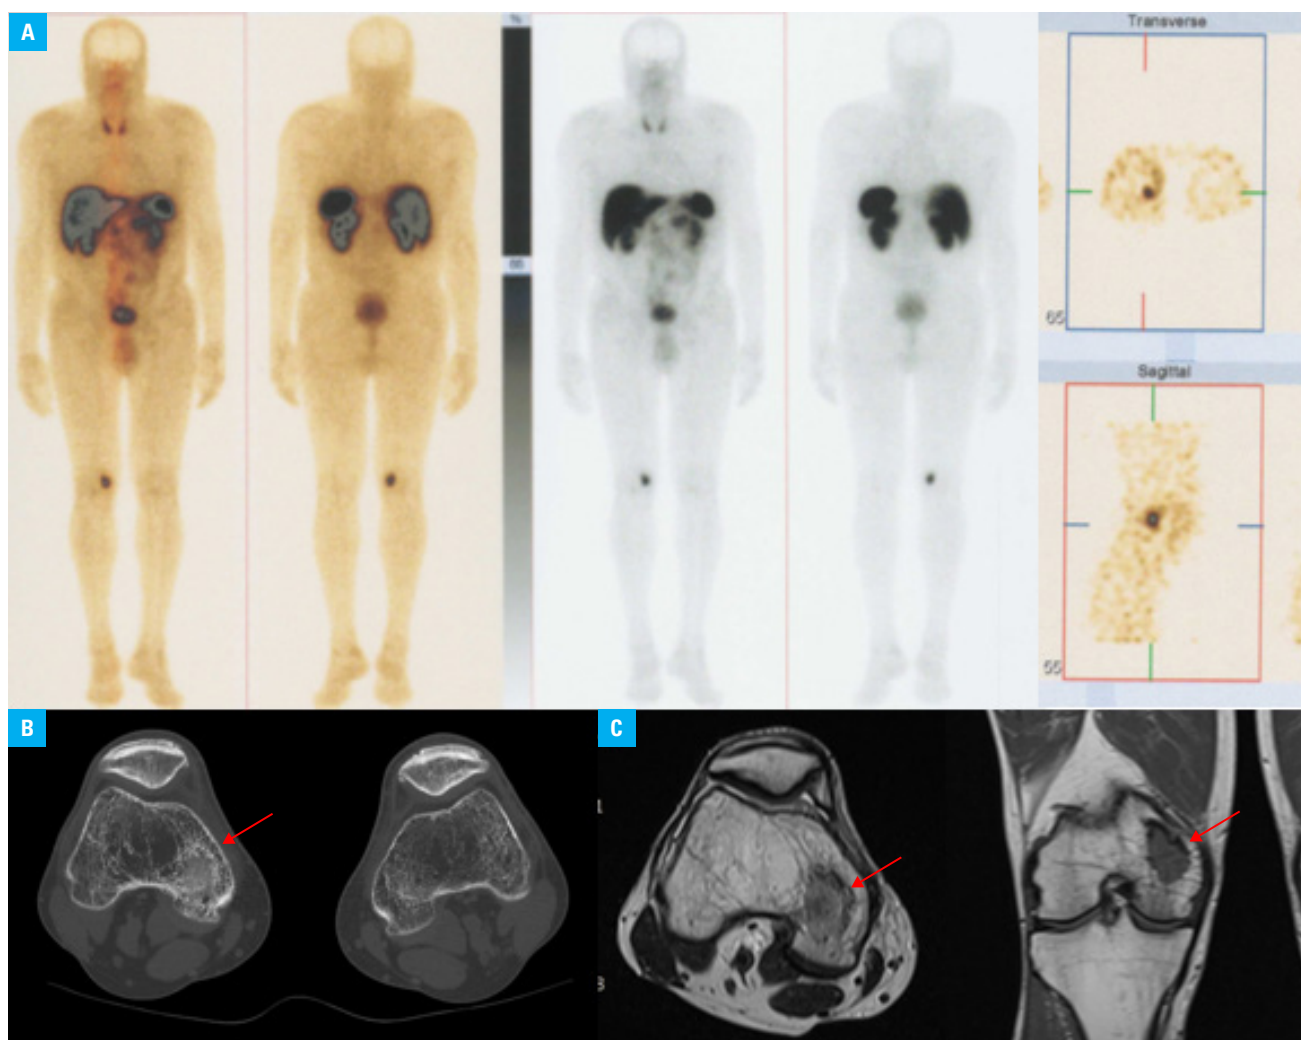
A – somatostatin receptor scintigraphy (^{99m}Tc -EDDA/HYNIC-Tyr3-octreotide): intense pathological radiotracer uptake in the right femoral epiphysis; B – computed tomography scan (transverse) of the right and left femoral epiphysis, with a visible phosphaturic mesenchymal tumor of blurred margins ($25 \times 18 \times 14$ mm) between the left epicondyle and condyle of the right femur (red arrow); C – magnetic resonance imaging of the right knee joint (coronal and axial sections), with a visible phosphaturic mesenchymal tumor (red arrows)
